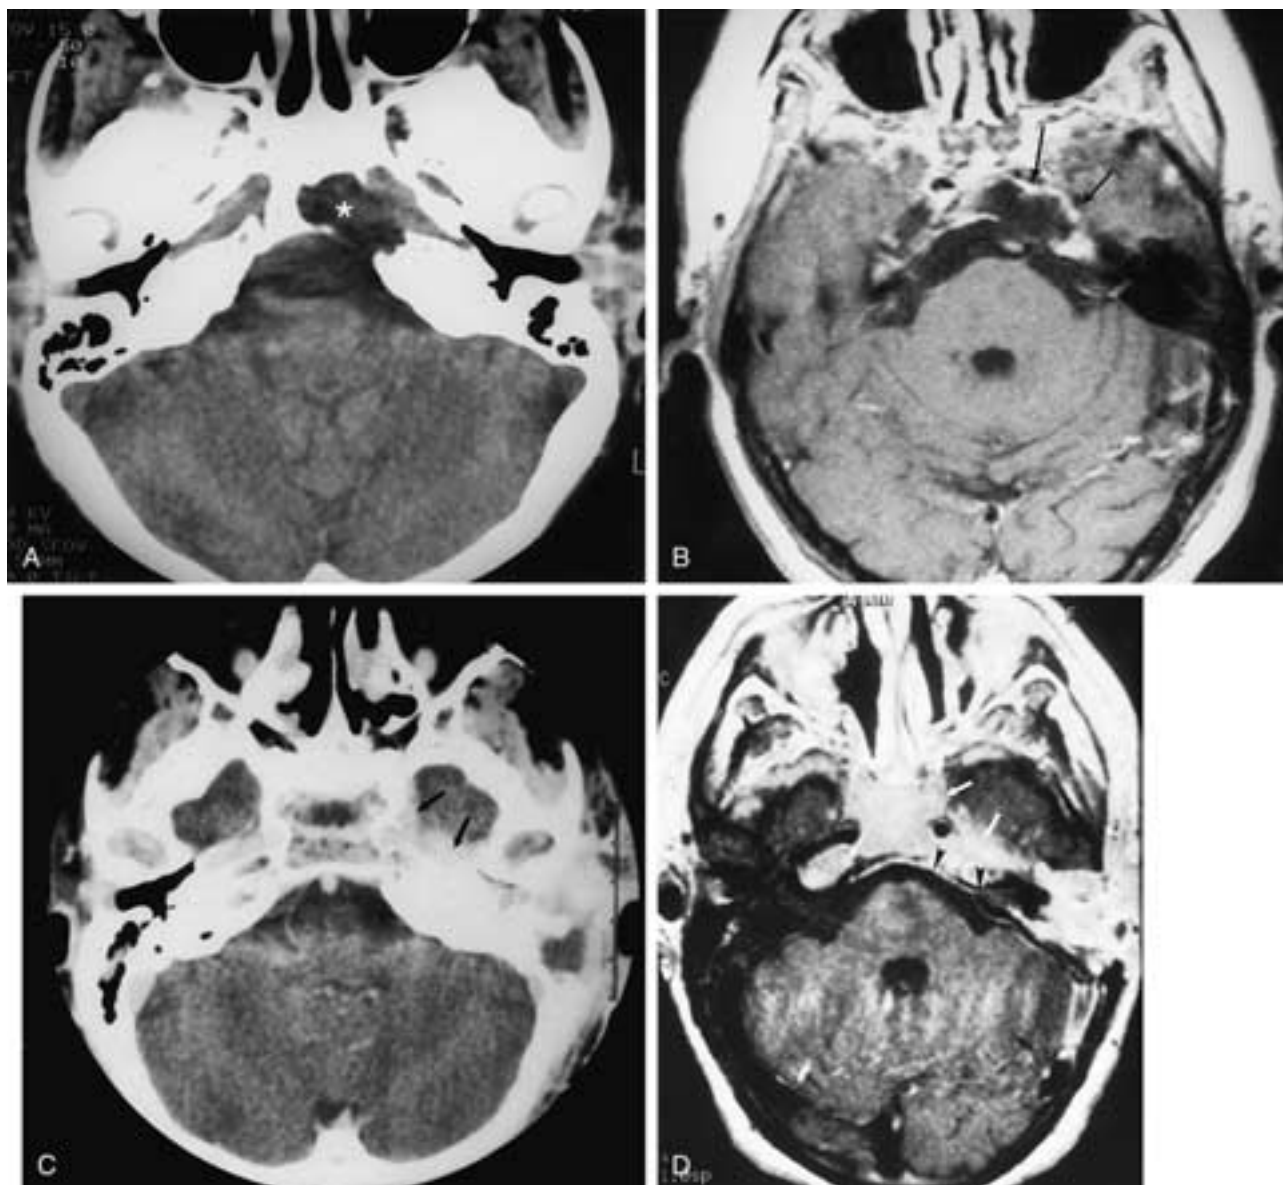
Petrous apicitis. A, Axial CT image, soft-tissue window. Debris is of low CT density (*asterisk*). B, Contrast-enhanced, T1-weighted axial image demonstrates contrast enhancement (*arrows*) along the periphery of the lesion, which is indicative of its inflammatory etiology. C, Different patient. Axial CT postcontrast scan shows enhancement (*arrows*) along the petrous apex extending to the cavernous sinus. The patient has had a mastoidectomy. D, T1-weighted postgadolinium image. Again, the enhancement (*arrows*) is seen extending along the petrous apex toward the cavernous sinus. There is enhancement (*arrowheads*) along the posterior fossa extending into the internal auditory canal. Comparison with the precontrast examination (not shown) showed that the high signal in the petrous apex represented enhancement. The opposite apex showed fat rather than enhancement.
